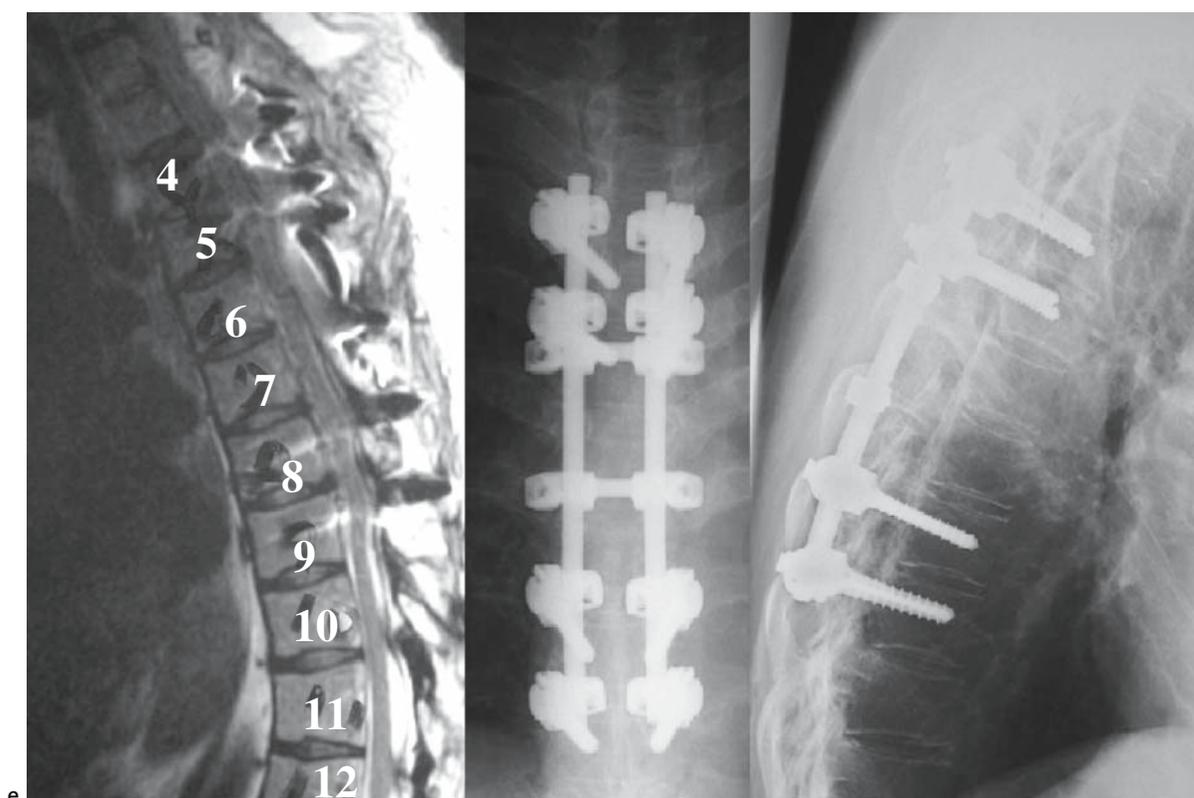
e Postoperative radiographs and MR images. The region with the maximum stenosis was decompressed via a transpedicular approach, and it was considered imperative to resect both the superior and inferior articular processes to
